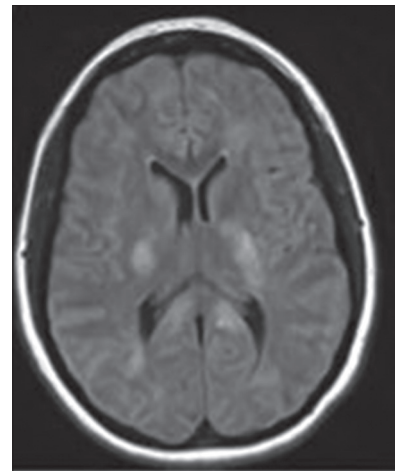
FLAIR axial MRI of a patient with ADEM showing bilateral high signal intensities in the posterior white matter
